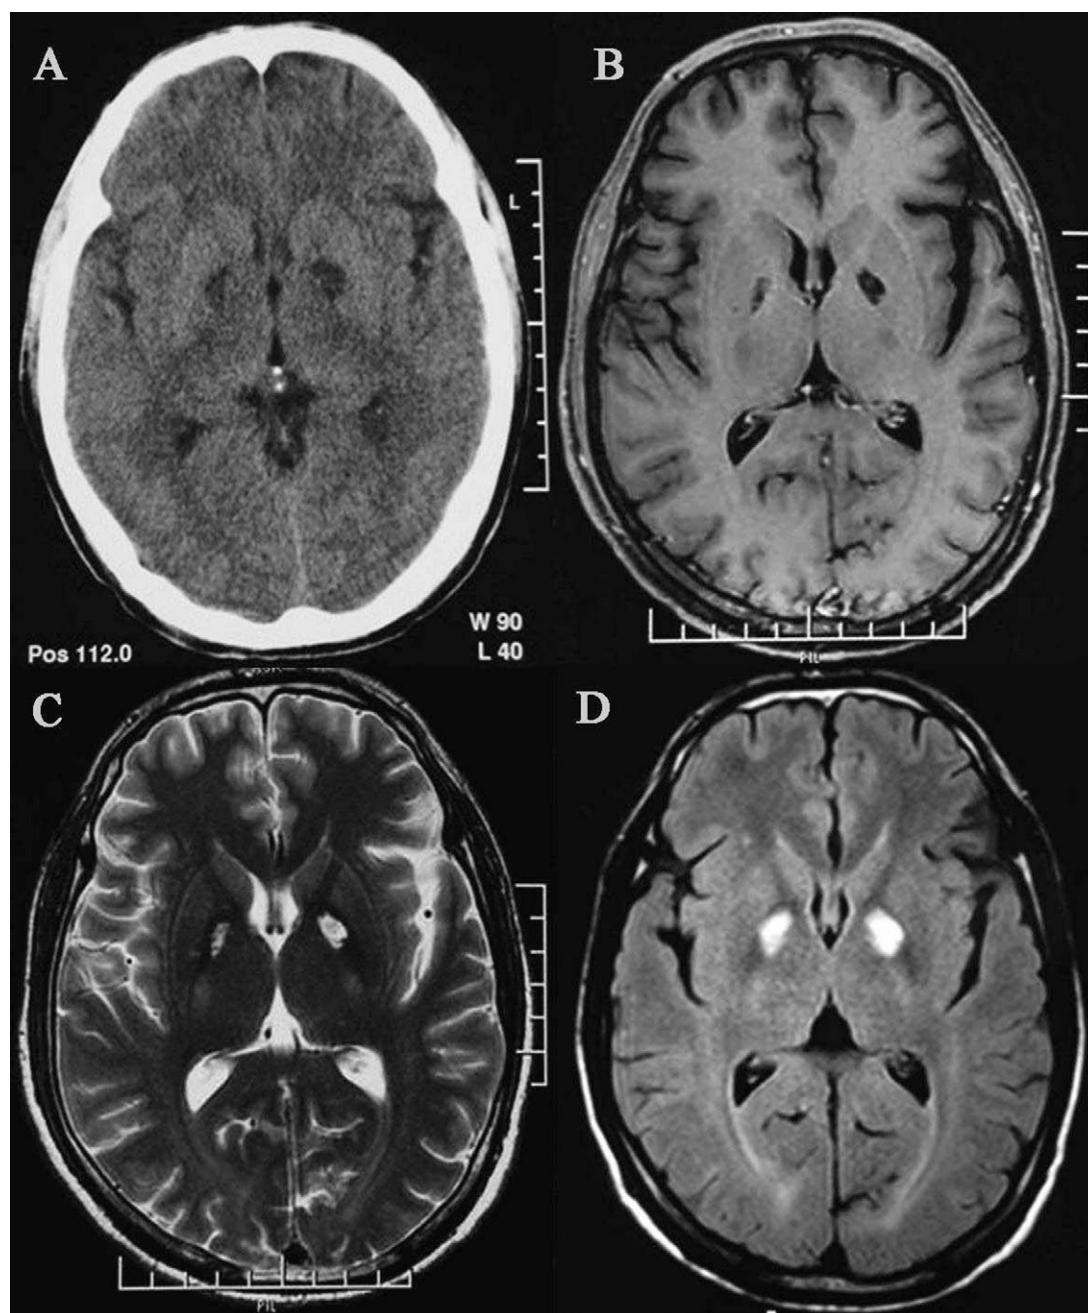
Images are obtained when the patient had been stung for 20 days and was admitted to local hospital. CT shows diffuse low density bilaterally in globus pallidus (A). Axial T1-weighted MR (B) image shows hypointensity in the same regions, and hyperintensity in T2-weighted (C) or fluid-attenuated inversion recovery (D) images.
